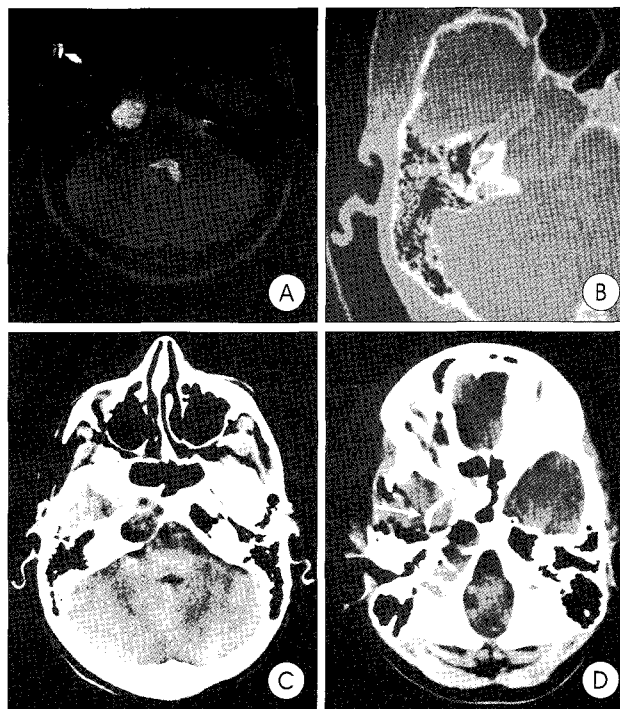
Preoperative magnetic resonance images and computed tomography (CT) scan of a large petrous apex cholesterol granuloma. A homogeneously hyperintense cystic lesion on the T2-weighted (A) images and well-marginated erosion in the tip of the right petrous apex (B) is noted. A hypodense oval-shaped cyst is demonstrated on the admission CT scan (C). Postoperative CT reveals the silastic catheter (arrow) which extends into the right sphenoid sinus (D).
